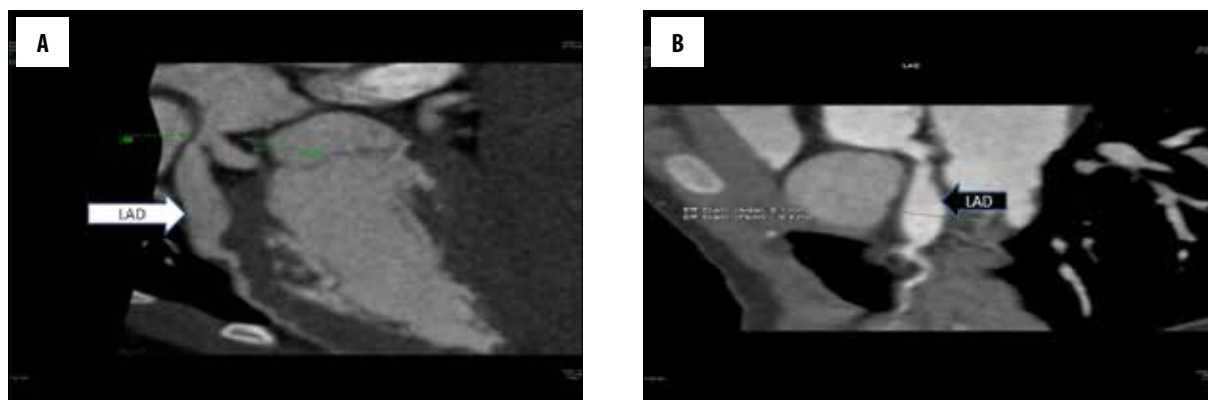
CT coronary angiography of a 5-year-old boy with Kawasaki disease. (A) Initial study: LAD artery aneurysm; (B) Follow-up study: stationary course of aneurysmatic dilatation of LAD artery.
